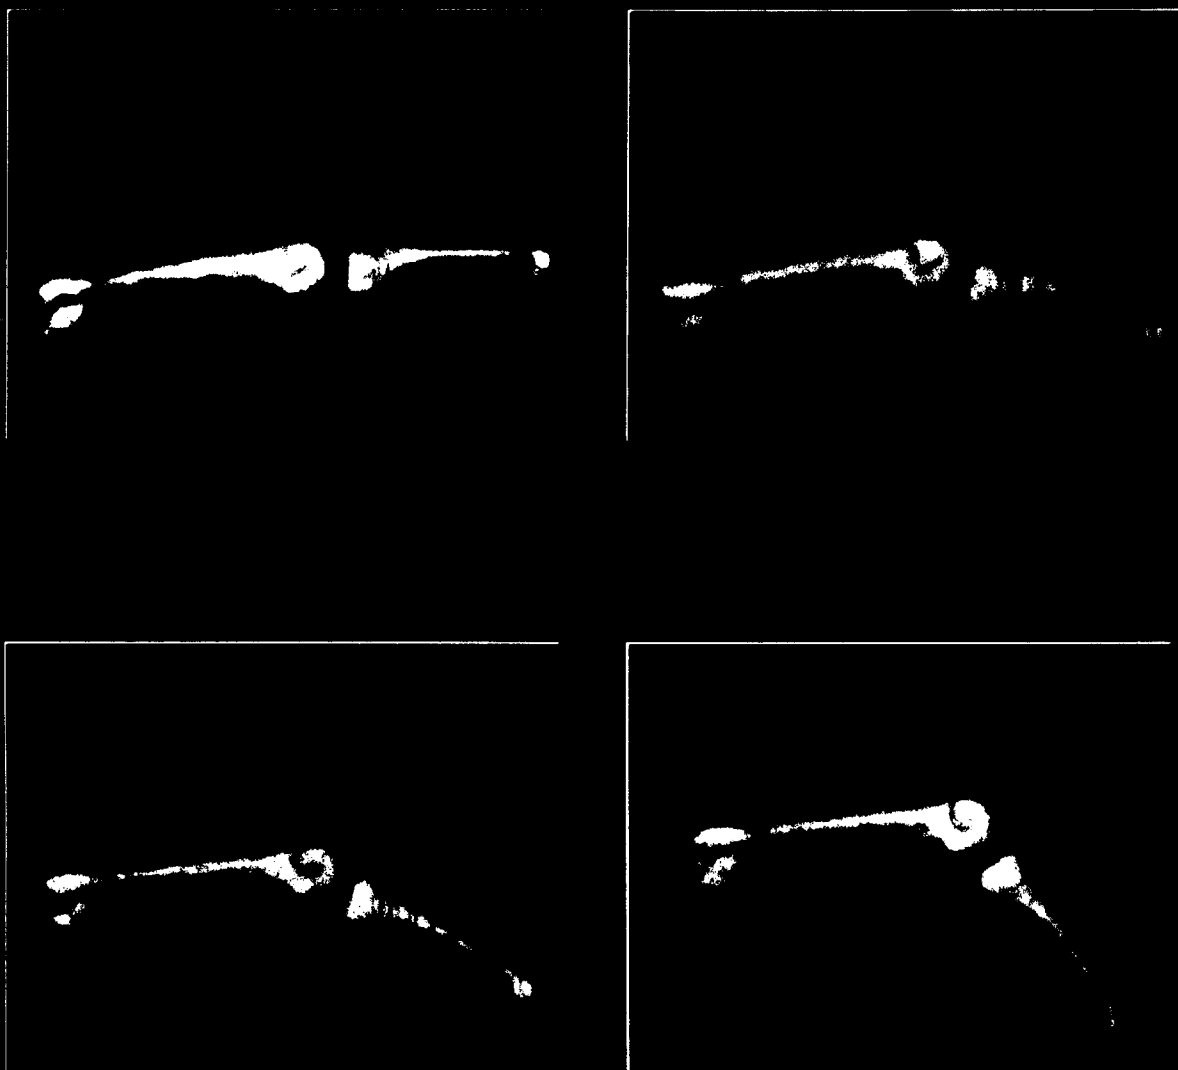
Using high resolution MRI, the middle finger is imaged near the MCP joint. The 4 images are obtained at different joint angles: 0.0, 19.31, 28.17, and 50.93 deg. Bones are segmented, and 3D images are obtained using a surface rendering algorithm. From such data, we obtain the joint axis of rotation and tendon moment arm. See text.
